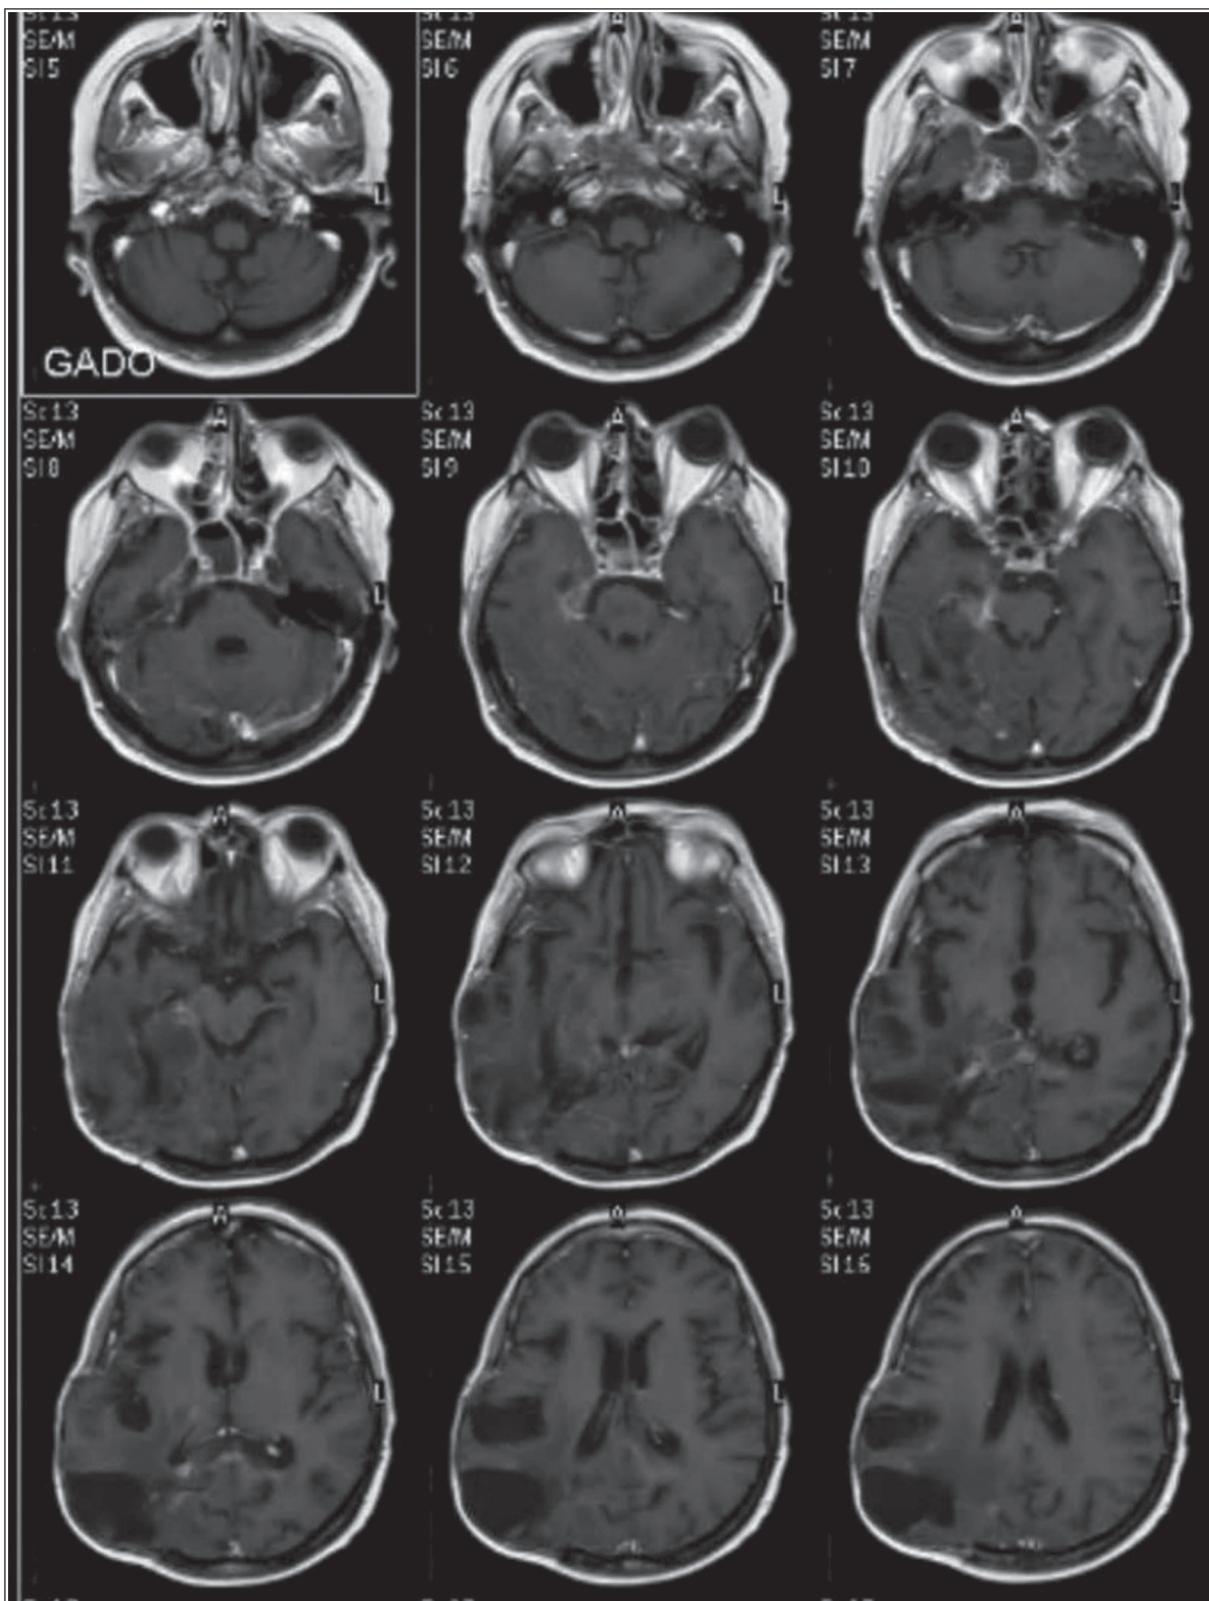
Post-chemotherapy (after six doses—3 months of Irinotecan and Bevacizumab) MRI T1 with contrast axial showing good response
